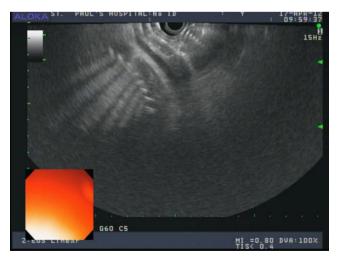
Transgastric endoscopic ultrasound (EUS) image of a fetal spine at 16-weeks gestation. The mother presented with biliary colic and resolving liver function abnormalities. EUS was negative for choledocholithiasis. The patient improved without undergoing ERCP
